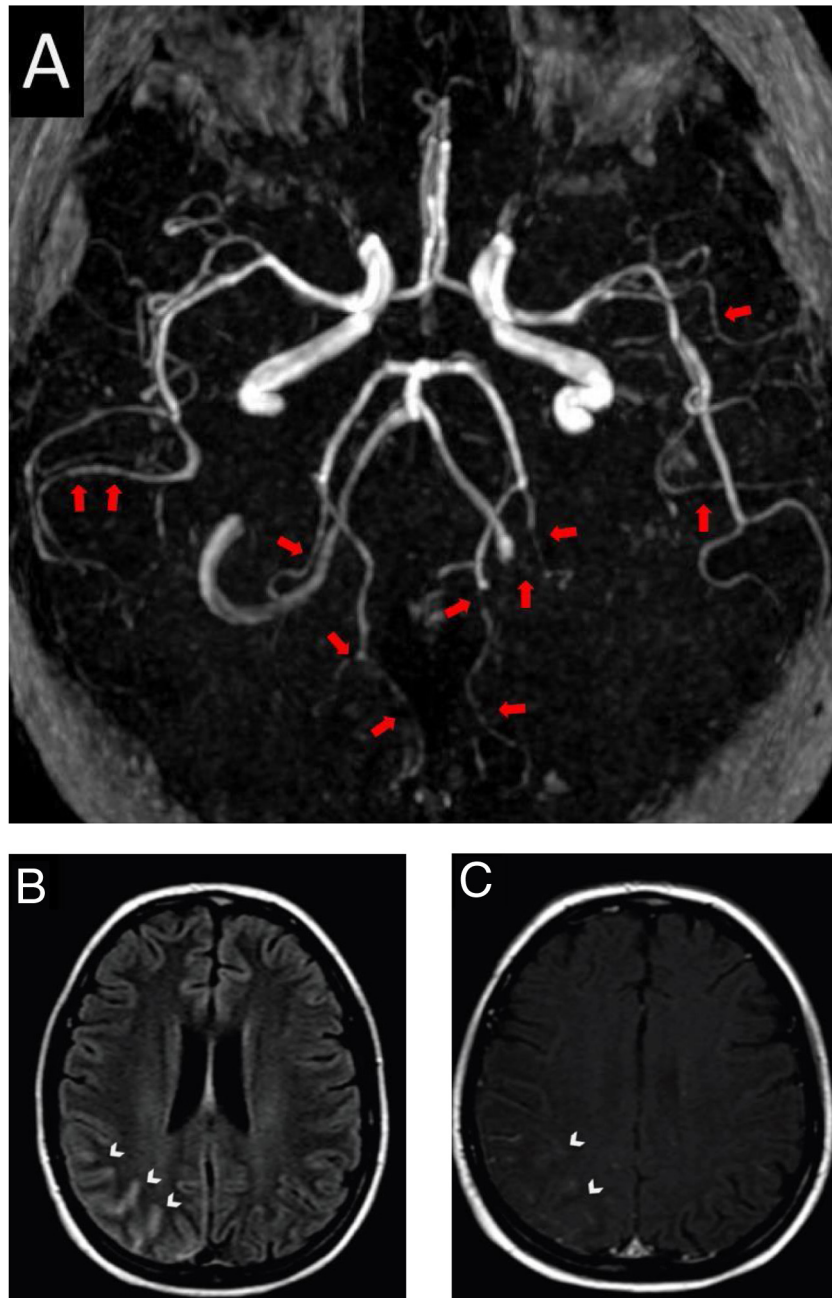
Brain magnetic resonance and angiography images. A, Angiography MRI showing segmental arterial constriction (red arrows). B, High intensity signal in the cortical sulcus and gyrus of the right parieto-occipital convexity on T2/Flair (white arrowheads). C, Slight impregnation of contrast in the leptomeningeal adjacent to the right parieto-occipital convexity on T1-GD (white arrowheads).
